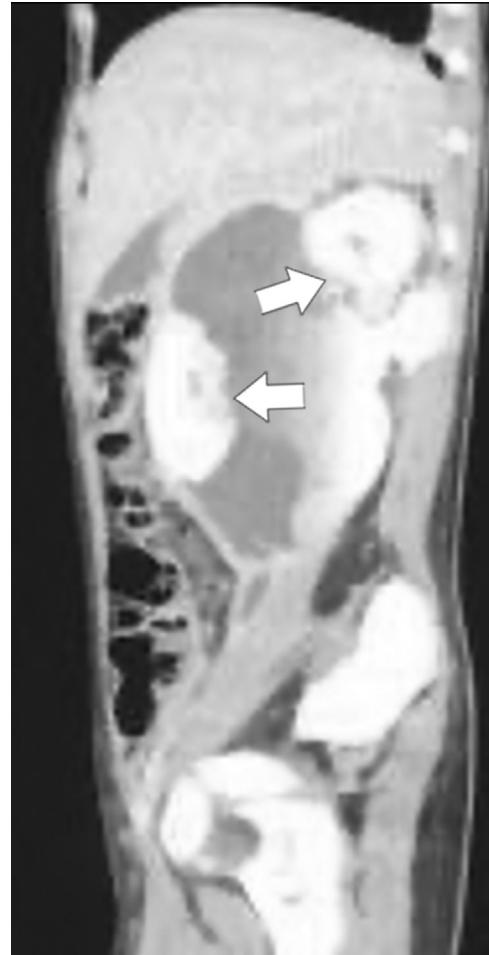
Sagittal view of the contrast-enhanced abdominal CT indicating a grade 5 renal trauma and urinoma.
